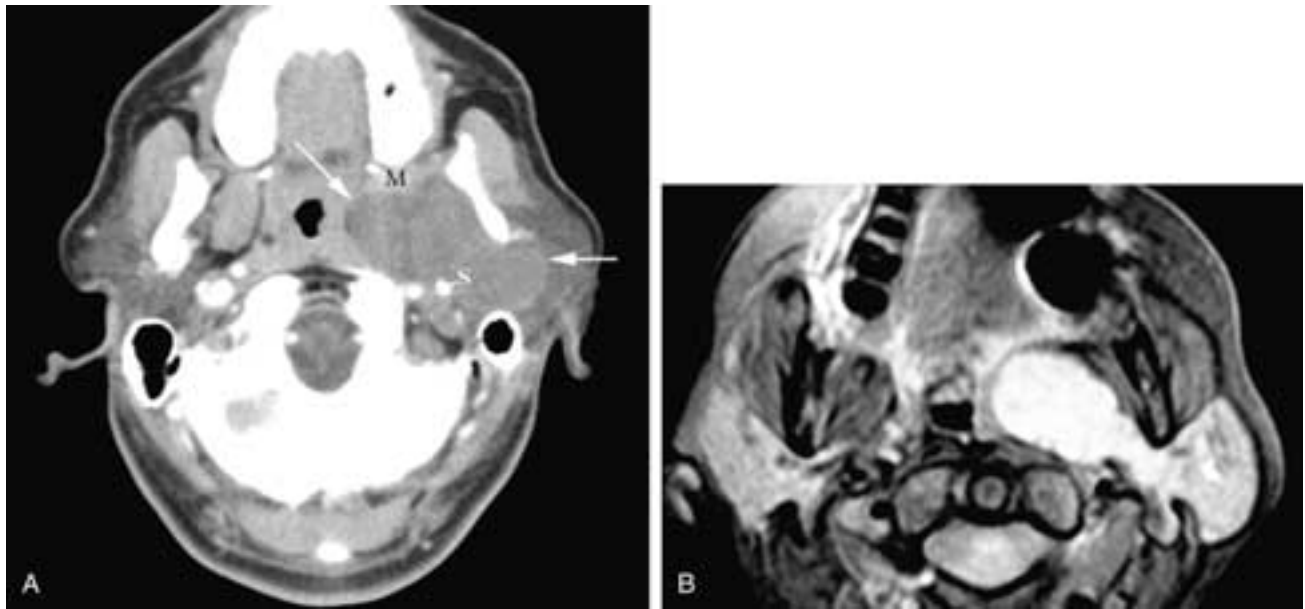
Axial contrast-enhanced CT scan (A) shows a pleomorphic adenoma (arrows) with near-water attenuation in the deep portion of the left parotid gland extending into the prestyloid compartment of the parapharyngeal space. The mass has displaced the internal pterygoid muscle (*M*) ventrally and had widened the stylomandibular tunnel. *S* represents the styloid process. The left pharyngeal wall has been displaced medially. Axial T1-weighted, fat-suppressed, contrast-enhanced MR image (B) shows a slightly dumbbell-shaped pleomorphic adenoma extending from the deep portion of the left parotid gland into the prestyloid compartment of the parapharyngeal space. The waist of the tumor is at the level of the rigid stylomandibular tunnel.
